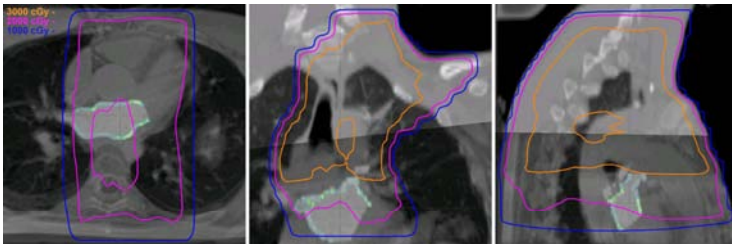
Blended CT/MRI with scar and radiation dose lines.
